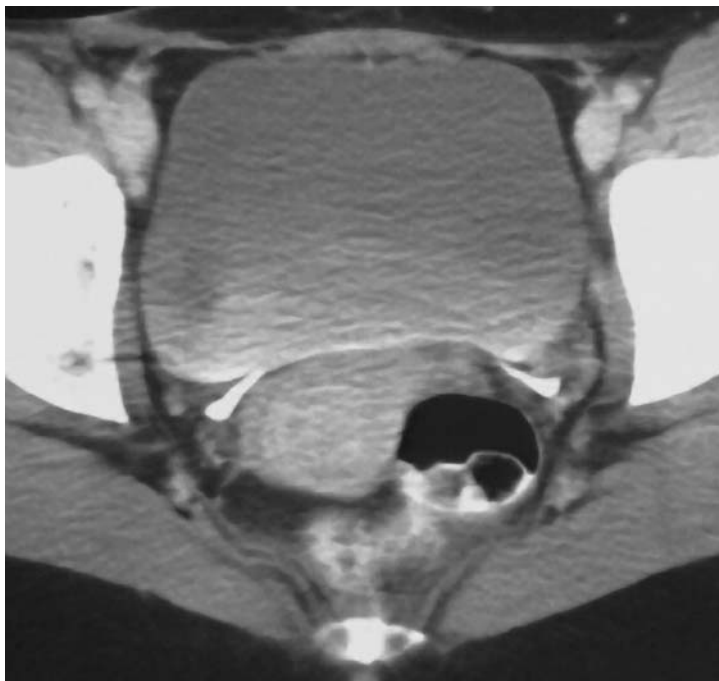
A computed tomography (CT) scan of the bladder showing the ureters entering posteriorly (outlined with contrast). The ureters enter the bladder just a few centimeters from the bladder neck and can easily be obstructed by locally advanced prostate cancer.
